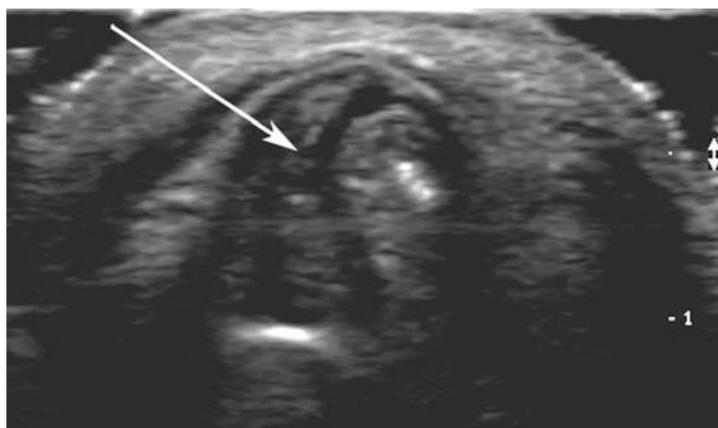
4. Sonogram shows lucency in the nasal septum (arrow).
